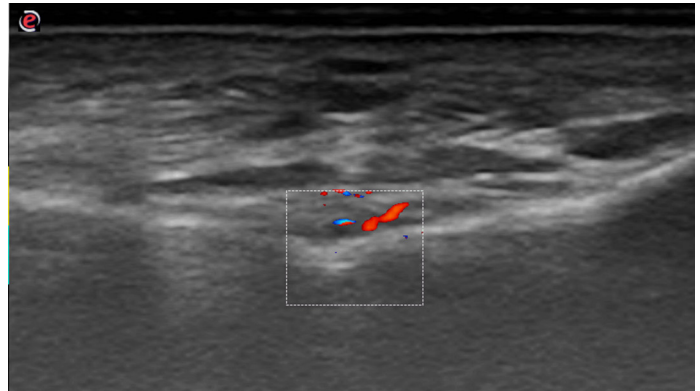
Ultrasonographic identification of infraorbital foramen, artery, and nerve. Images sourced from the archive of Dr. Ilteris Ahmet Senturk
